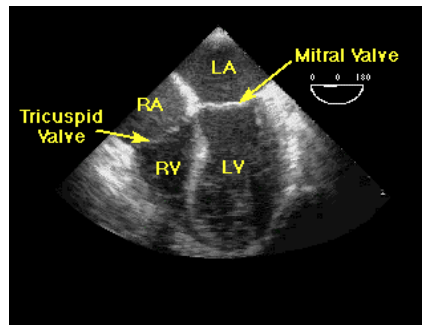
Echocardiogram. RA: Right Atrium, LA: Left Atrium, RV: Right Ventricle, LV: Left Ventricle. The tricuspid and mitral valves are pointed out (Enc. Of Science 2011)
